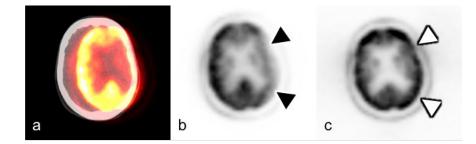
Misregistration due to motion. Misregistration due to patient motion between CT and PET acquisition after injection of ¹⁸F-FDG (a) results in a large area of apparent reduced uptake along the periphery of the left cerebral hemisphere (closed arrowheads) on the attenuation corrected (AC) PET images (b). Symmetric uptake in this area on the non-AC images (open arrowheads) confirms the artifactual nature of this finding (c).
